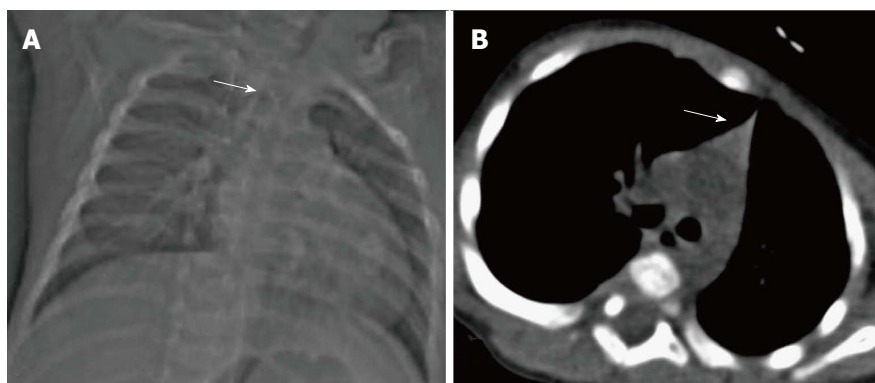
Thymic hypoplasia in a 3-mo-old male infant with primary immunodeficiency. CT scanogram (A) reveals small size of the thymus, i.e., less than twice the width of the third thoracic vertebra (arrow). NCCT chest axial section (B) shows triangular configuration of the thymus (arrow) with straight margins (normal appearance in adolescents). Compare this with the normal appearance of the thymus in a 2-mo-old infant (Figure 6A and B).
